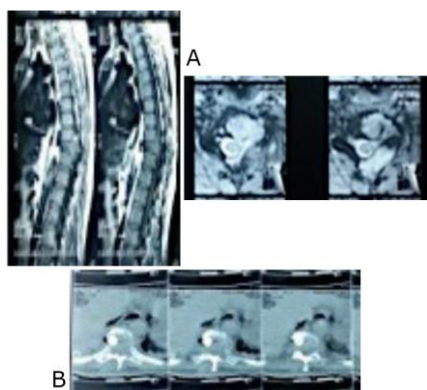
A) Preoperative Sagittal T1WI and Axial T2WI; B) Postoperative Axial CT scan after pyra mesh insertion
